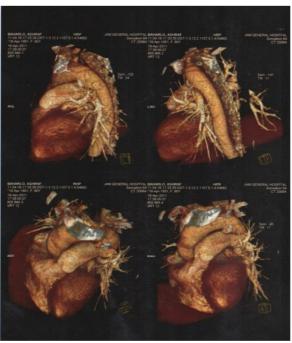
Computed tomographic angiographic findings
